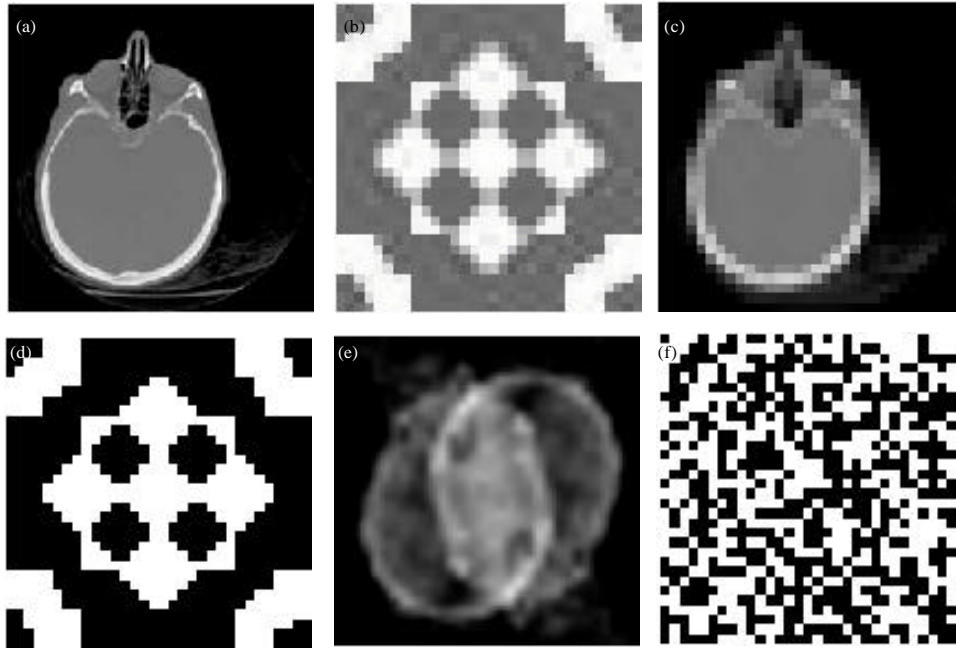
(a-f): Outputs of CT image watermarking, (a) Original CT image, (b) Original watermark, (c) Spatial domain recovered image, (d) Spatial domain extracted watermark, (e) FFT recovered image and (f) FFT extracted watermark
